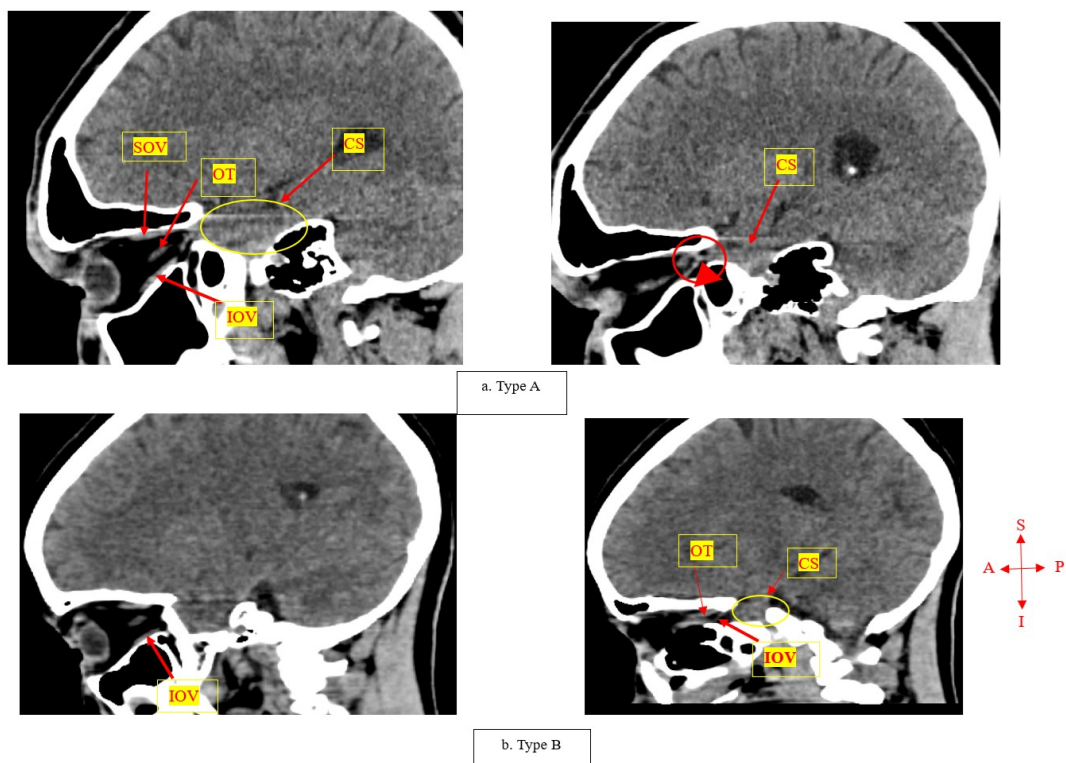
Sagittal CT images showing the different drainage patterns of the inferior ophthalmic vein; Type A – drains into the superior ophthalmic vein before draining into the cavernous sinus; Type B – drained directly into the cavernous sinus bypassing the superior ophthalmic vein (images by Cele *et al.*, 2026).
